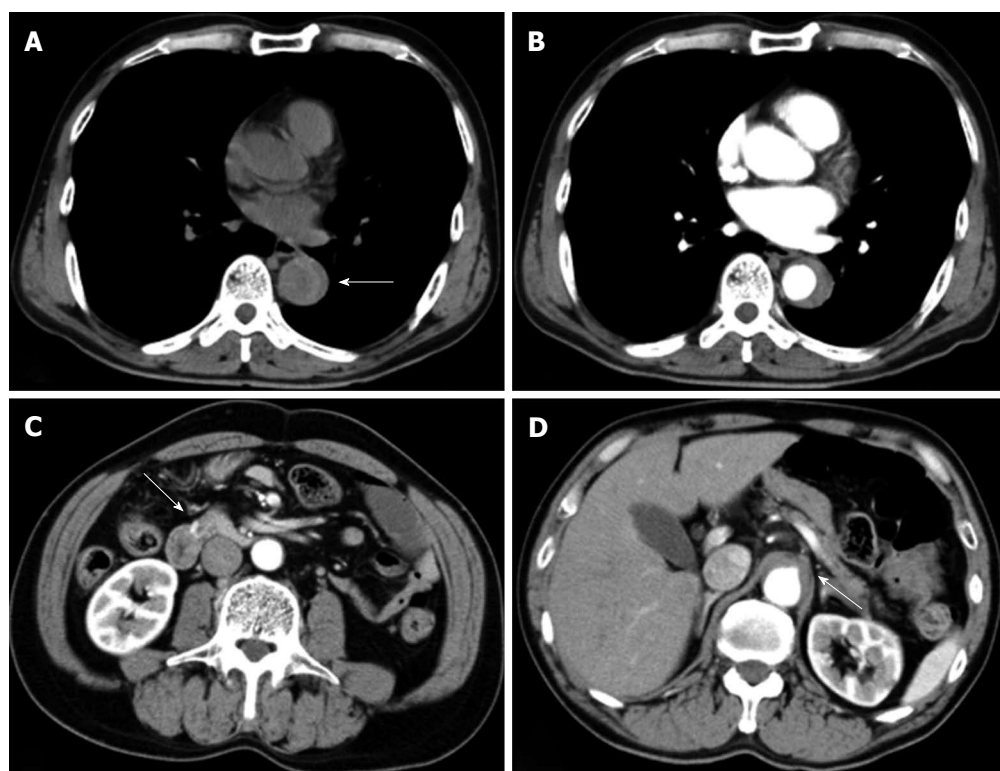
Initial computed tomography performed at local hospital before the onset of hypotension. A: Plain computed tomography (CT) demonstrating dilated descending aorta and hyperattenuated collection located eccentrically within the aortic wall (arrow); B: Contrast-enhanced CT revealed crescentic and asymmetric wall thickening of the descending aorta: Contrast is not visualized within the aortic media. Intimal flap was not detected; C: An aneurysm at the anteroinferior pancreaticoduodenal artery (arrow); D: The occluded root of the coeliac artery (arrow).
